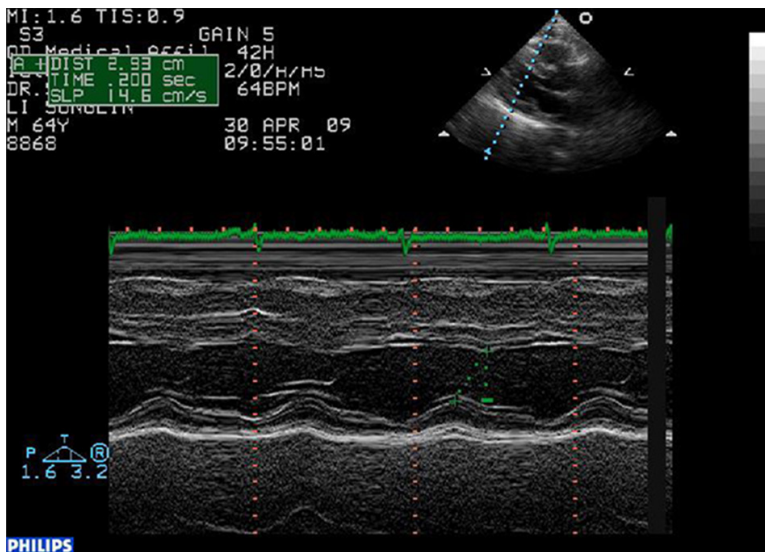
M-mode echocardiography measuring septal-to-posterior wall motion delay (SPWMD)-the duration from peak ventricular septum contraction to the peak of left ventricular posterior wall contraction.
